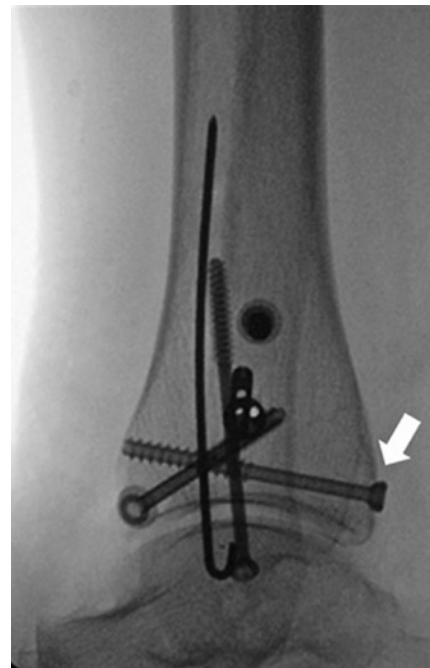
Lateral radiograph showing the final position of the percutaneous posteroanterior screw (white arrow).
